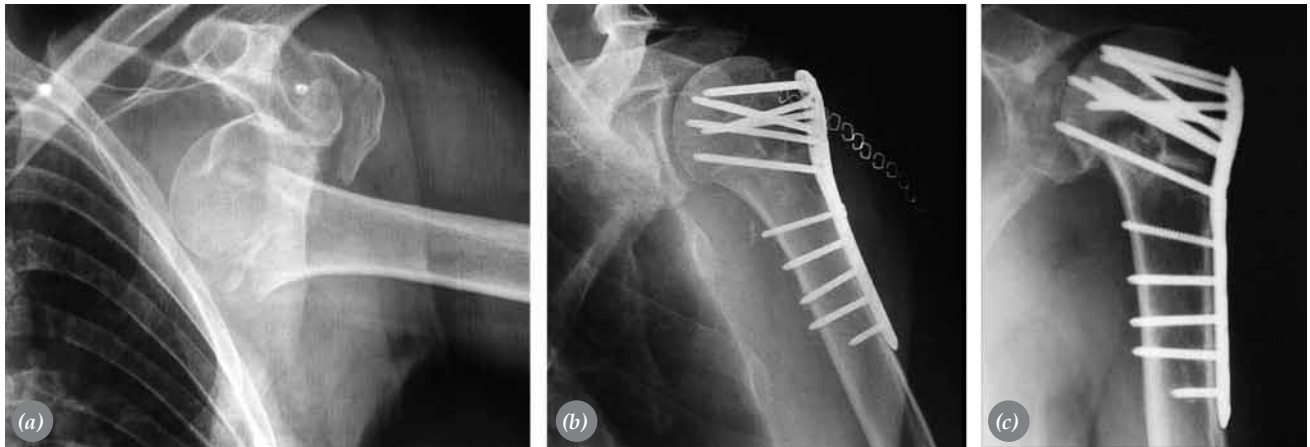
(a) The anteroposterior radiograph of a 69-year-old man with a four-part fracture dislocation of the left humerus occurring after a fall. (b) Immediate postoperative radiograph shows anatomical reduction, internal fixation of the fracture, and a stable medial column. (c) Radiograph of the fracture at postoperative 12 months shows partial collapse of the humeral head and penetration of the screws into the joint.
